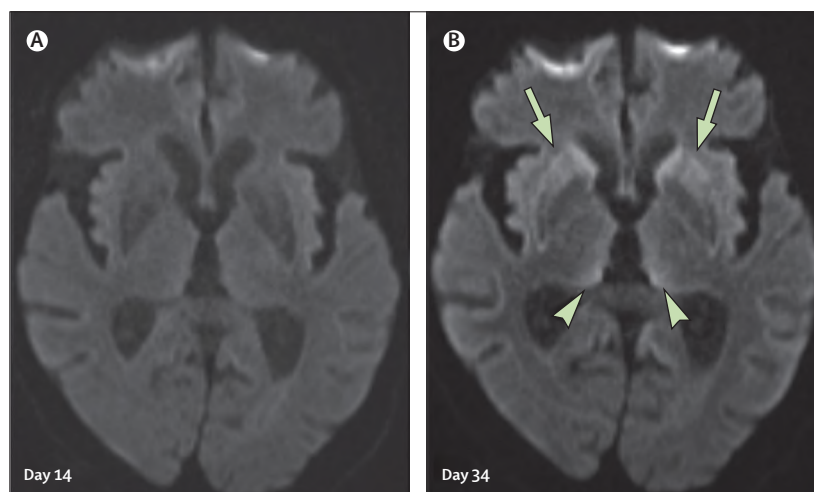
MRI changes in Borna disease virus 1 encephalitis. Diffusion-weighted MRI (A) on day 14 shows no abnormalities, but on day 34 (B) scan shows diffusion restriction in the basal ganglia (arrows) and the pulvinar (arrowheads).
